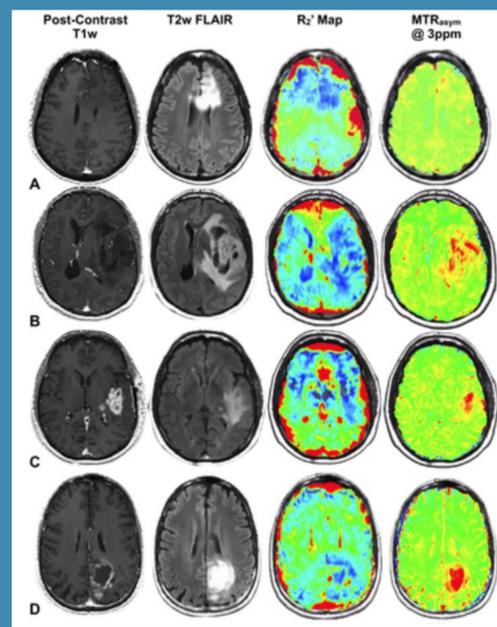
Appearance of gliomas using various MRI scan types⁹
